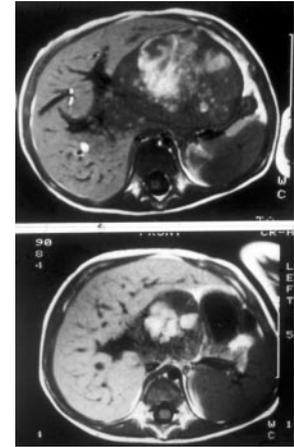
MRI scan of hepatoblastoma in a 2-year-old boy pre- and post- four courses (12 weeks) of "PLADO" chemotherapy. The tumor has shrunk dramatically and the abdomen and liver have a much more normal contour.
